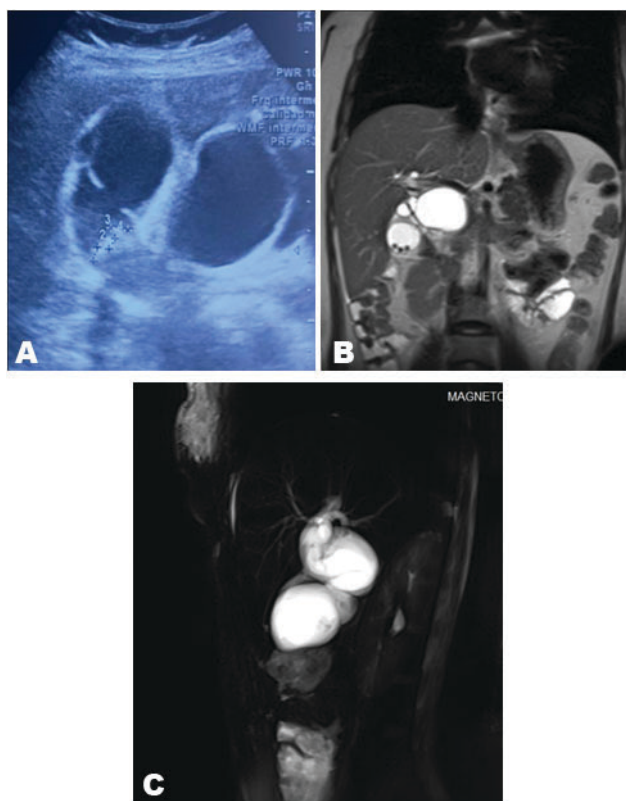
(A) Abdominal echography revealing the choledochal cyst. (B) MRI, Todani IA cyst. (C) MRI, Todani IA cyst.
